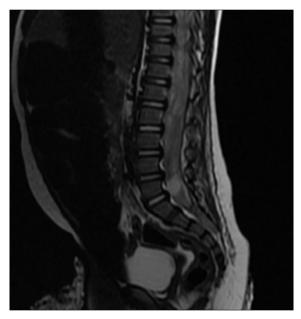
T2 MRI spine saggital-showing hyperintense intraspinal abscess.
